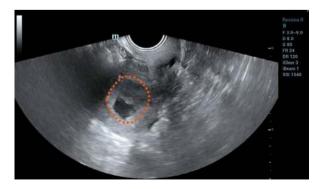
(a) Ultrasound shows diffuse thickening of the endometrium with mixed low to moderate echogenicity. (b) Color Doppler shows abundant blood flow signals within and around the endometrium. This patient's pathology revealed severe atypical hyperplasia of the endometrium with focal malignant changes
